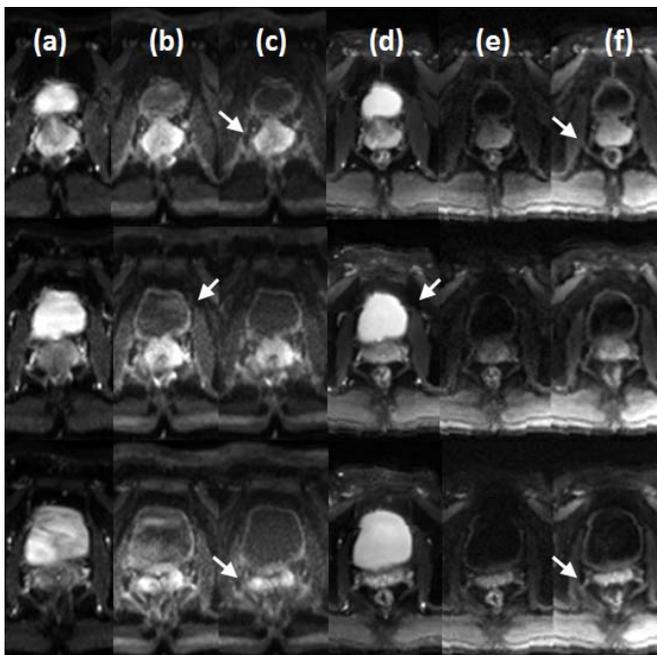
The comparison between two DWI results. (a) b=0; (b) b=800; (c) b=1000; (d) b=0; (e) b=800, (f) b=500. The left three columns are EPI-DWI; the right three columns are VDS-DWI.
